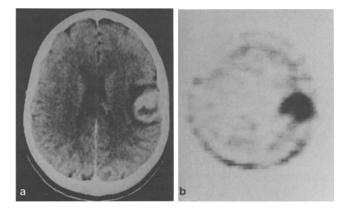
Corresponding CT (left) and PET (right) slices of a metastasis of a highly malignant mesenchymal tumor with an accumulation ratio of 2.6 $\,$
